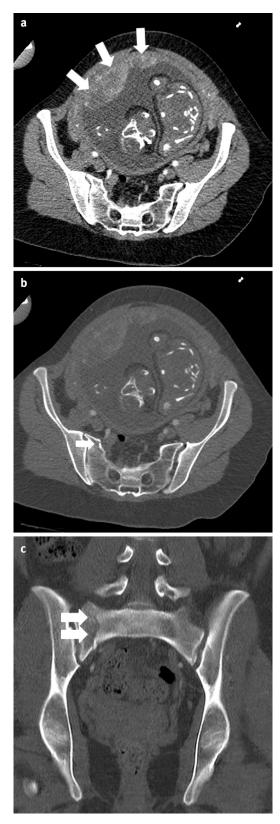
CT scan of the abdomen and pelvis (with IV contrast) of a pregnant patient involved in a high speed road traffic accident. (a) Axial image (soft tissue windowing) showing the gravid uterus and anterior placenta (arrows), (b) axial image (bone windowing, arrows), (c) coronal image (bone windowing) showing a right sacral fracture (arrows)
